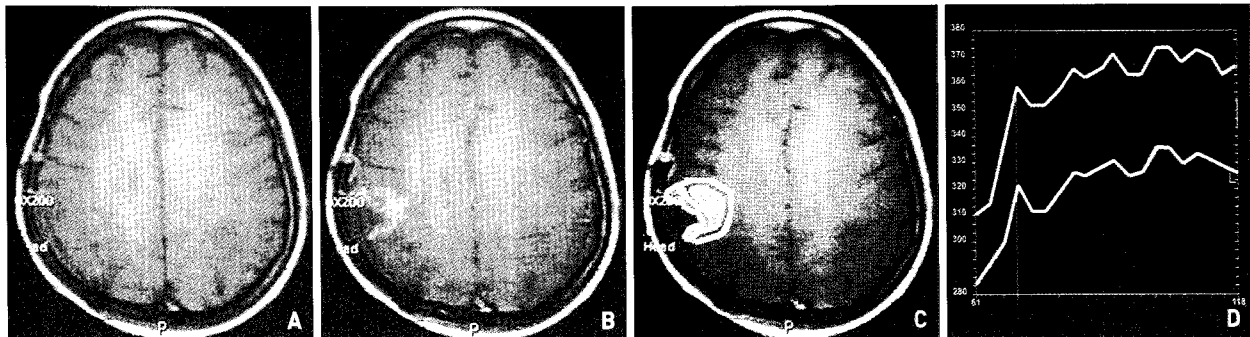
A 44-year-old female patient with glioblastoma multiforme in the right temporoparietal area (case 4). Tumor removal was done followed by irradiation with 59.4 Gy. Magnetic resonance images of the brain and dynamic scan were taken 4 months later. A : T1-weighted axial image. B : Enhancement is noted after administration of Gd-DTPA. C : Region of interest for enhancing (yellow) and surrounding (white) areas. D : "T pattern" is noted in both areas on dynamic scan.
